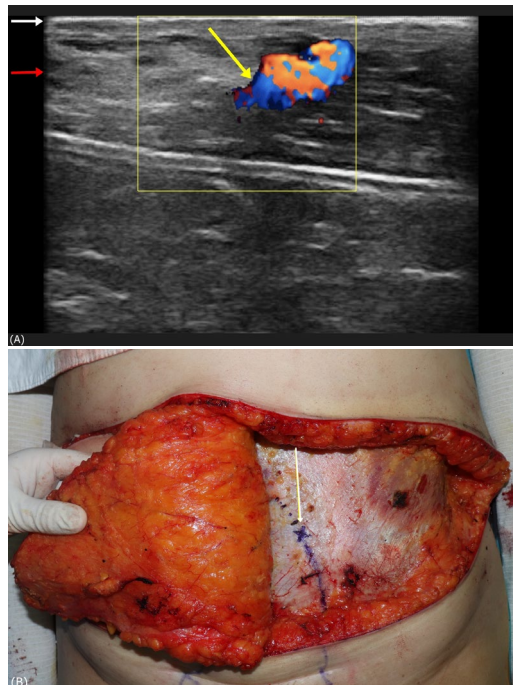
(A) Portable color Doppler ultrasound visualized the vascular pedicle beneath the flap tissue. Arrow; *Yellow*. Deep inferior epigastric artery perforator intramuscular course, *Red*. Rectus abdominis muscle, *White*. Rectus sheath (B) Gross intraoperative view showing the elevated flap and marked presumed pedicle course. Reduced overlying tissue thickness during debulking improved ultrasound visualization, allowing safer tissue reduction and helping prevent pedicle injury.
